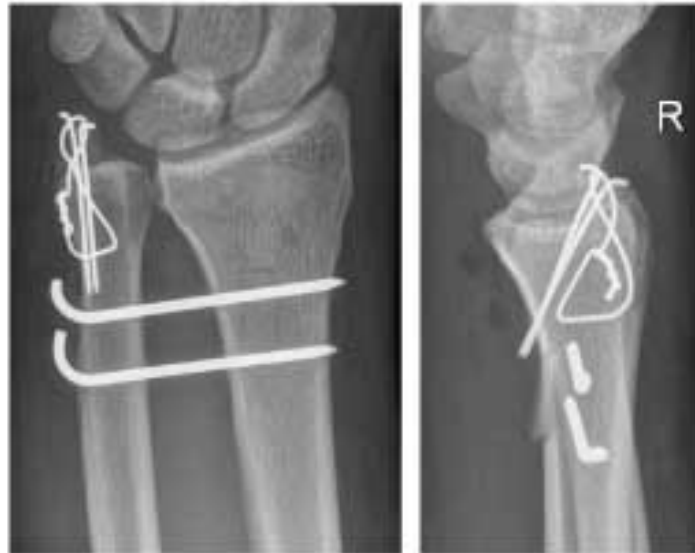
Radiograph in two planes postoperatively
